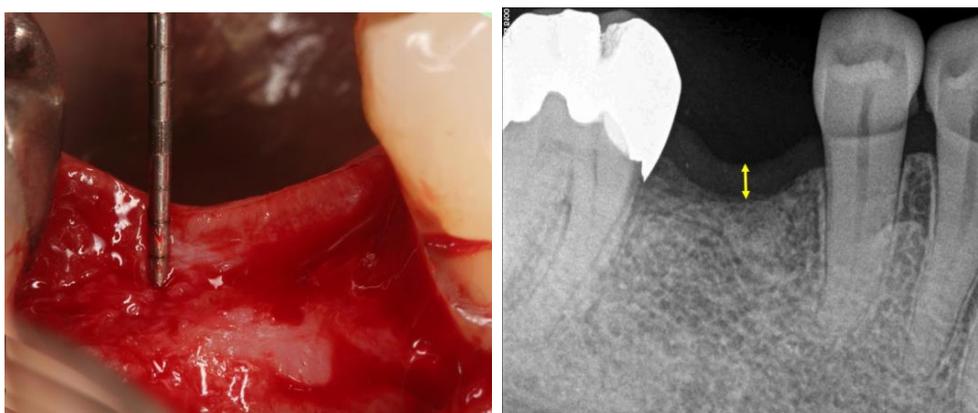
Representative clinical image of the mucosal thickness measurement after the mucosal flap and a periapical x-ray image of the mucosal measurement.
